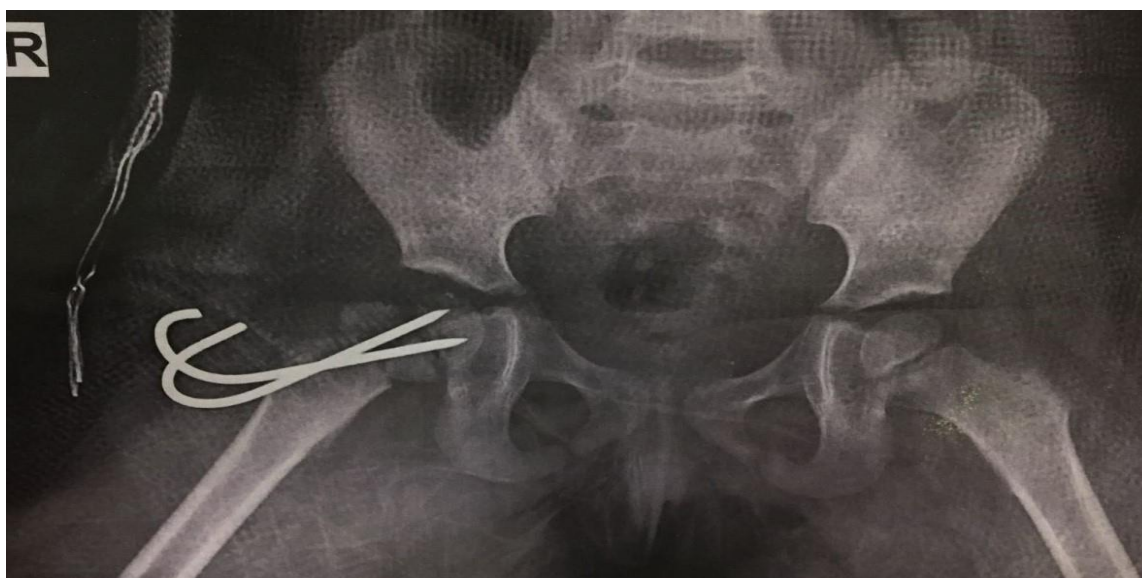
Initial post-op radiograph.
